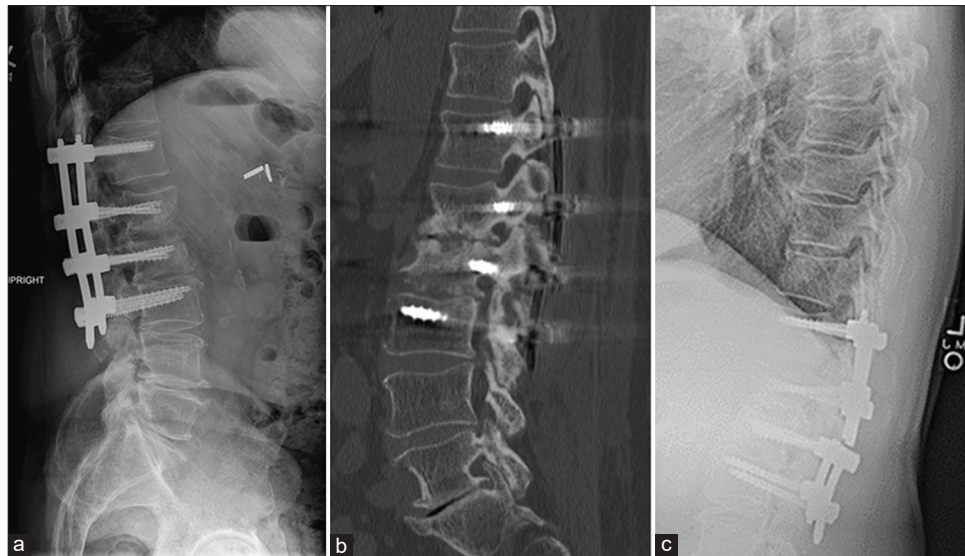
Post standalone percutaneous fixation scans (a) lateral X-ray post 8 months, (b) CT scan post 9 months. Reconstitution of L1 vertebral volume is 40.80 cm³ and L2 volume is 35.08 cm³. (c) Lateral X-ray 11-month post fixation showing broken rods at L1-2.
